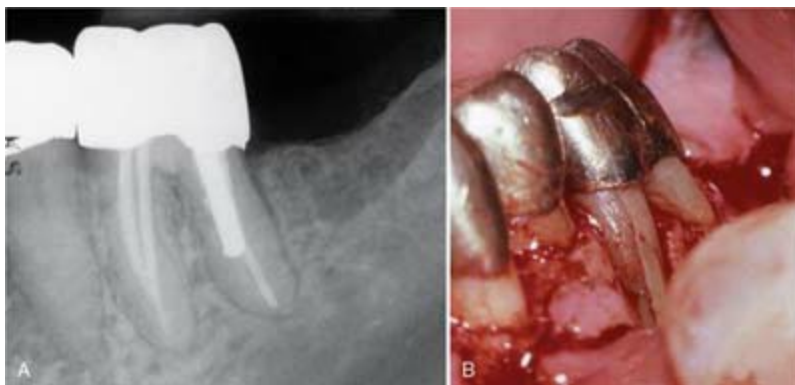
Vertical root fractures can occur with excessive compaction forces. A, Follow-up radiograph of a mandibular left first molar. A deep isolated periodontal probing defect was associated with the buccal aspect of the mesiobuccal root. B, Flap reflection revealed a vertical root fracture.
